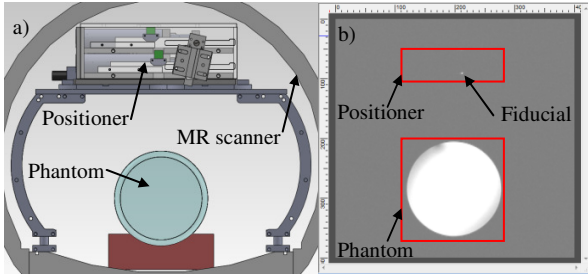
CAD model of the positioner in the MR scanner (a); corresponding axial MR image with the positioner powered on (b).
